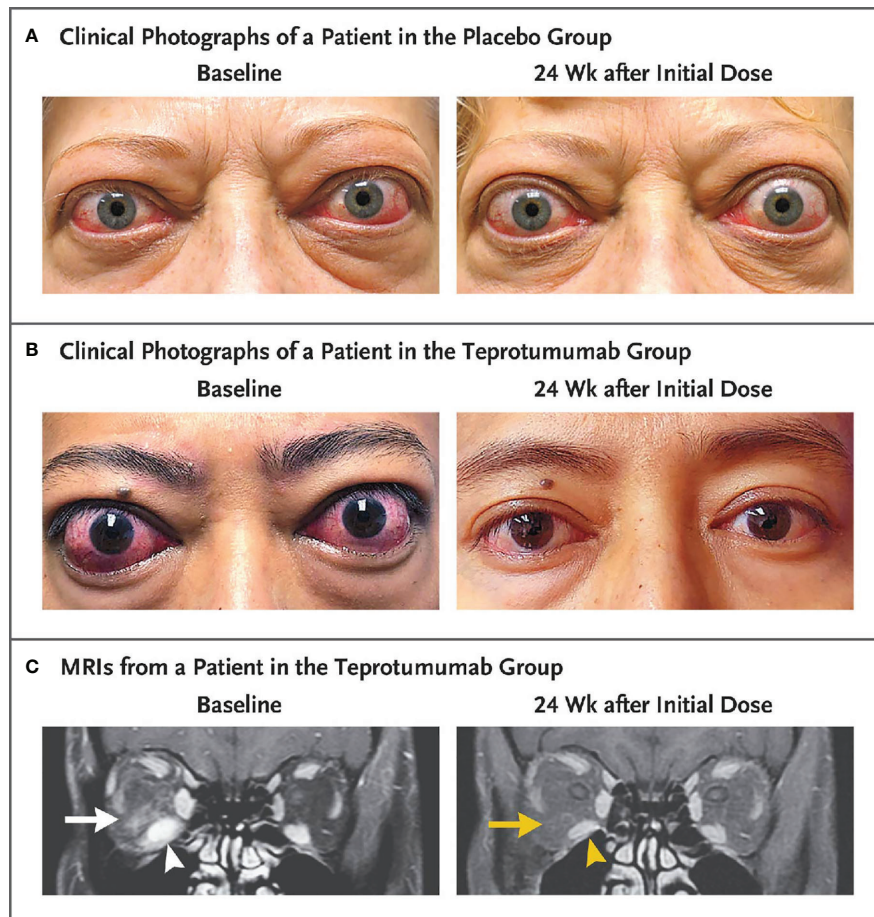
Facial photographic images and MRIs at Baseline and 24 Weeks following treatment with either placebo or teprotumumab in patients enrolled in the Phase 3 trial. Panel (A) Clinical photographs of a patient receiving placebo. At baseline, the patient exhibits substantial proptosis (left eye, 29 mm and right eye, 27 mm) as well as multiple inflammatory signs (left eye Clinical Activity Score of 7 and right eye 5). At week 24, considerable proptosis and inflammatory signs remain. (B) Images of a teprotumumab-treated patient. Baseline proptosis (both eyes 24 mm), edema, upper and lower eyelid retraction, and multiple inflammatory signs (CAS 5 bilaterally). At week 24, considerable bilateral reductions in proptosis (~5 mm) and CAS (~4 points). (C) Coronal, contrast-enhanced, fat-saturated, T1-weighted MRIs in a single patient receiving teprotumumab at baseline and at week 24. Note marked enhancement of the inferior rectus muscle (white arrowhead) and orbital fat (white arrow) as well as inferior rectus muscle enlargement. At week 24, resolved inferior rectus muscle (yellow arrowhead) enhancement and orbital fat (yellow arrow). The muscle volume was reduced by 49% (yellow arrowhead). Proptosis reduction decreased from 23 mm at baseline to 18 mm at week 24. From N. Engl. J. Med, Douglas R.S., Kahaly G.J., Patel A., Sile E.H.Z., Thompson R. et al. Teprotumumab for the treatment of active thyroid eye disease. 382; 341-352. Copyright © (2020) Massachusetts Medical Society. Reprinted with permission.
